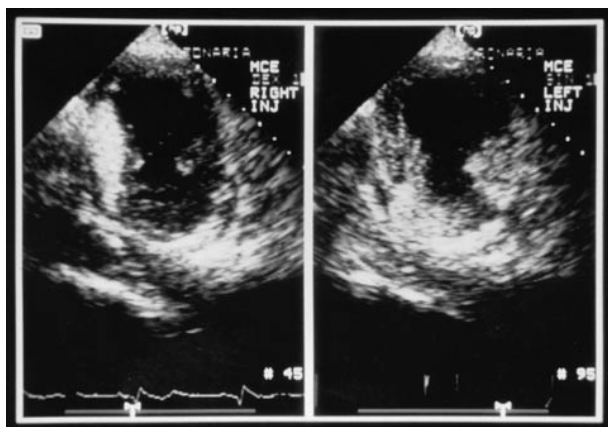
This figure shows a myocardial contrast echo (MCE) study of a patient with acute myocardial infarction of the anterior wall in whom the infarct-related artery was patent. Selective contrast injection of sonicated Ioxaglate into the right coronary artery (left panel) depicts the perfusion bed of the right coronary artery. However, when the contrast agent was injected into the left infarct-related coronary artery (right panel), the anterior wall showed a clear perfusion defect indicative of no-reflow, a sign of irreversible damage of the microvascular network. The intramyocardial perfusion pattern did not correlate with the angiographic patency of the infarct-related vessel, thus myocardial contrast echocardiography provided additional valuable information on myocardial perfusion after infarct.
